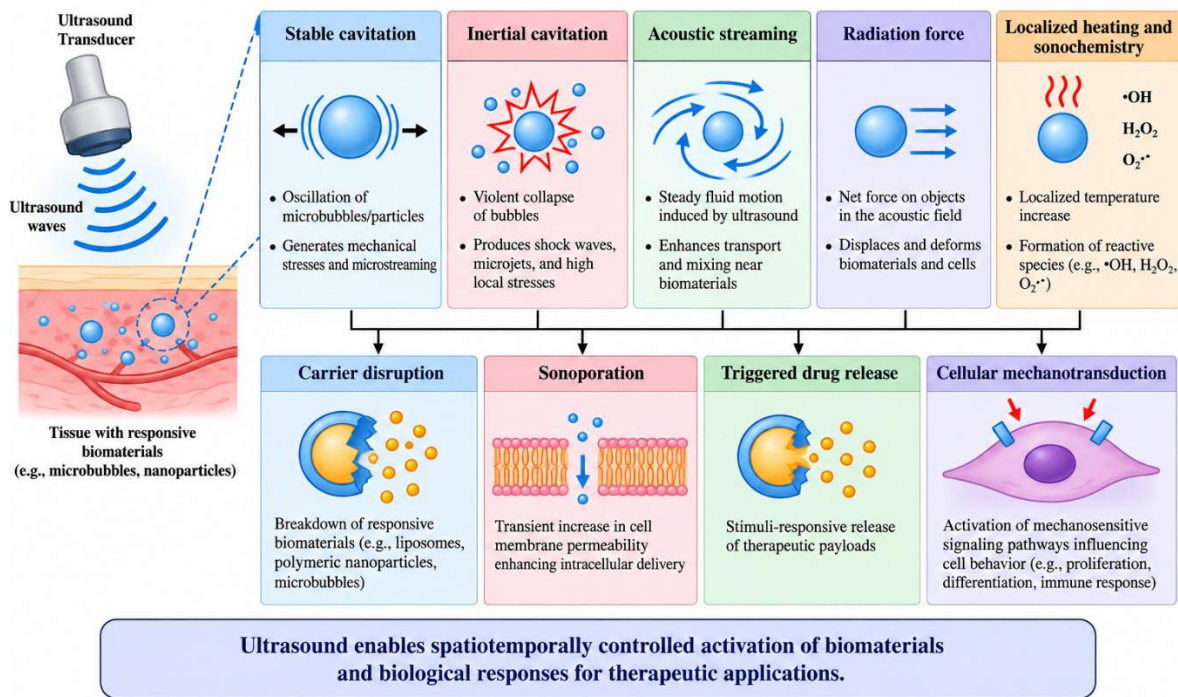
Conceptual mechanisms of ultrasound activation.
